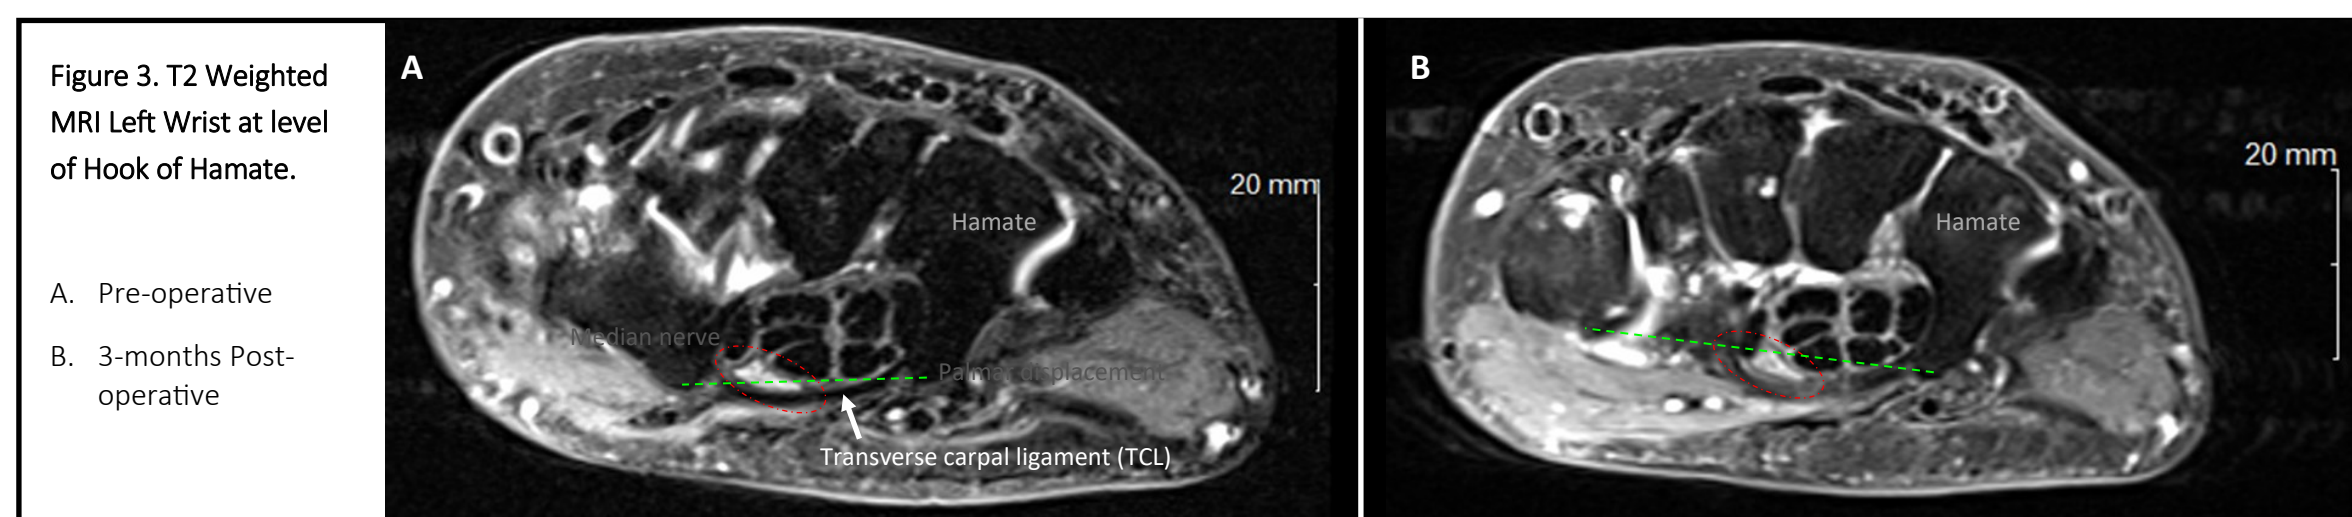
T2 Weighted MRI Left Wrist at level of Hook of Hamate.
